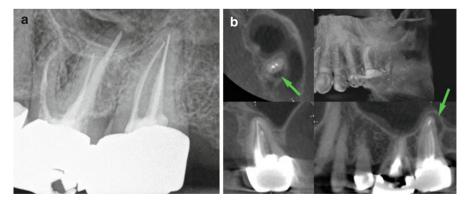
(a) Periradicular radiograph of a maxillary second molar tooth. (b) CBCT of the same tooth clearly showing a region of radiolucency at the distal apical aspect of the tooth; (green arrows)
